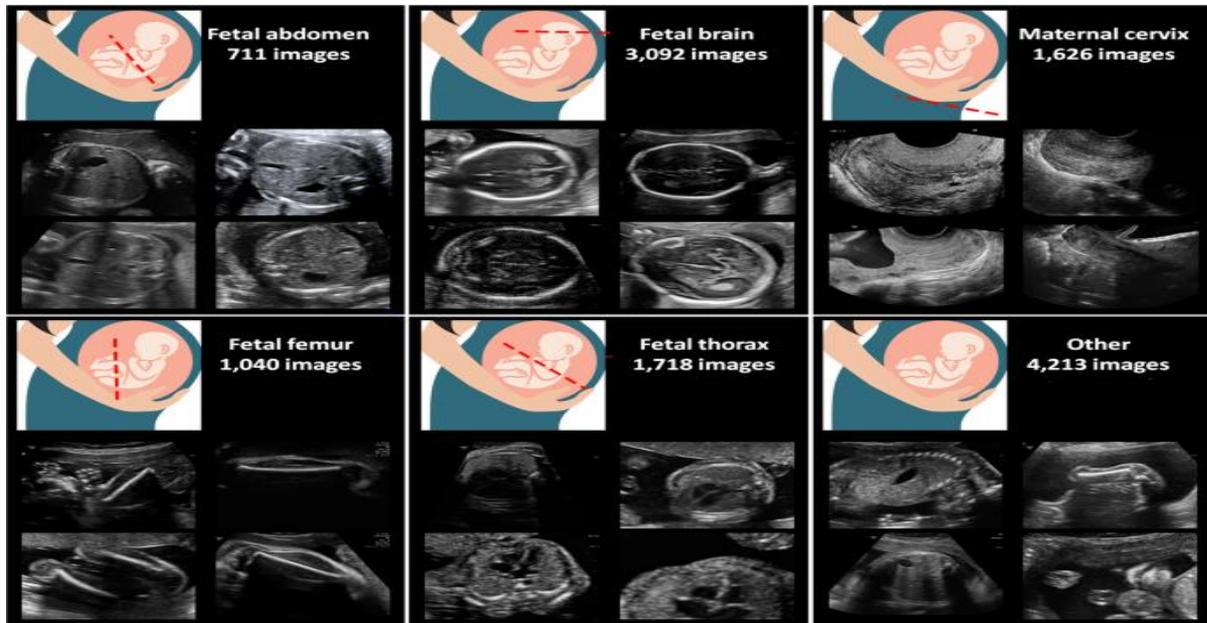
Ultrasound images display planes of volume acquisitions. [6].
